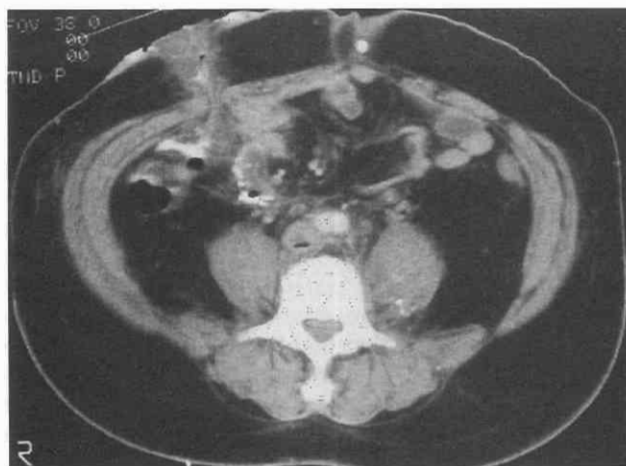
Infected inferior vena cava thrombus. Enhanced CT scan shows a punctate collection of air adjacent to inferior vena cava thrombus. This indicates infection in this patient with a right lower quadrant ostomy.
